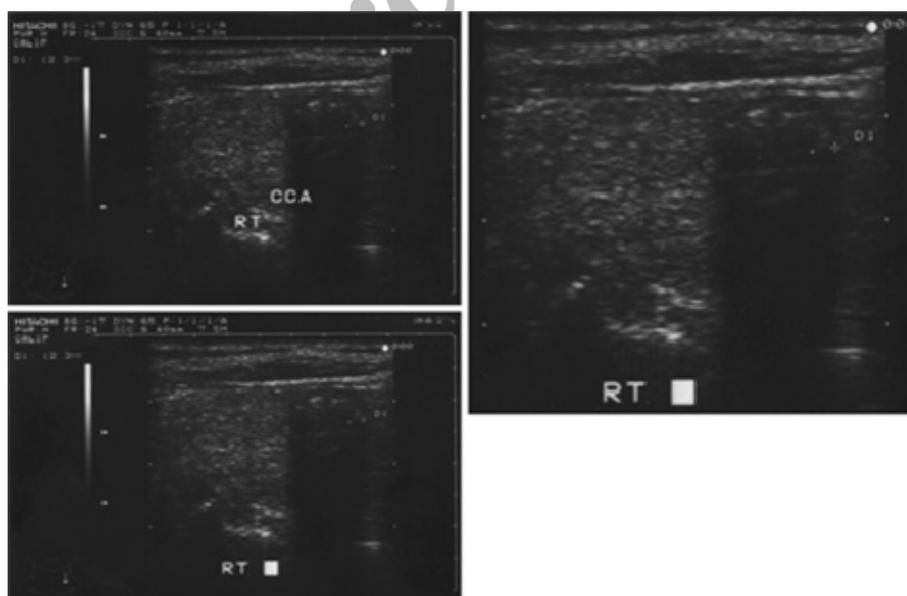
Ultrasonography of a 70- year-old man who was referred for carotid Doppler before coronary artery bypass graft. The image shows an incidental hyperechoic nodule with posterior shadow.
